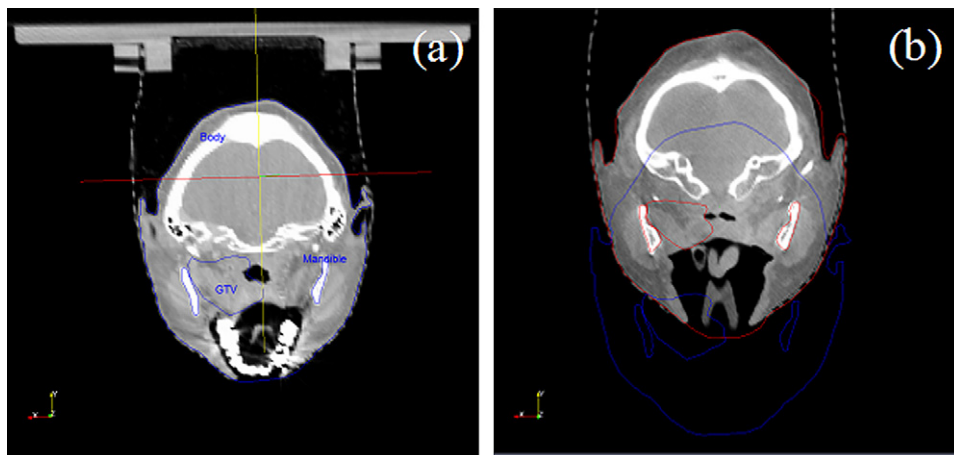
Contour propagation in a head-and-neck case. (a) Planning computed tomography with manually outlined template contours (in blue) for body, mandible, and gross tumor volume. (b) Cone-beam computed tomography along with contours after warping (in red) for the corresponding structures.
